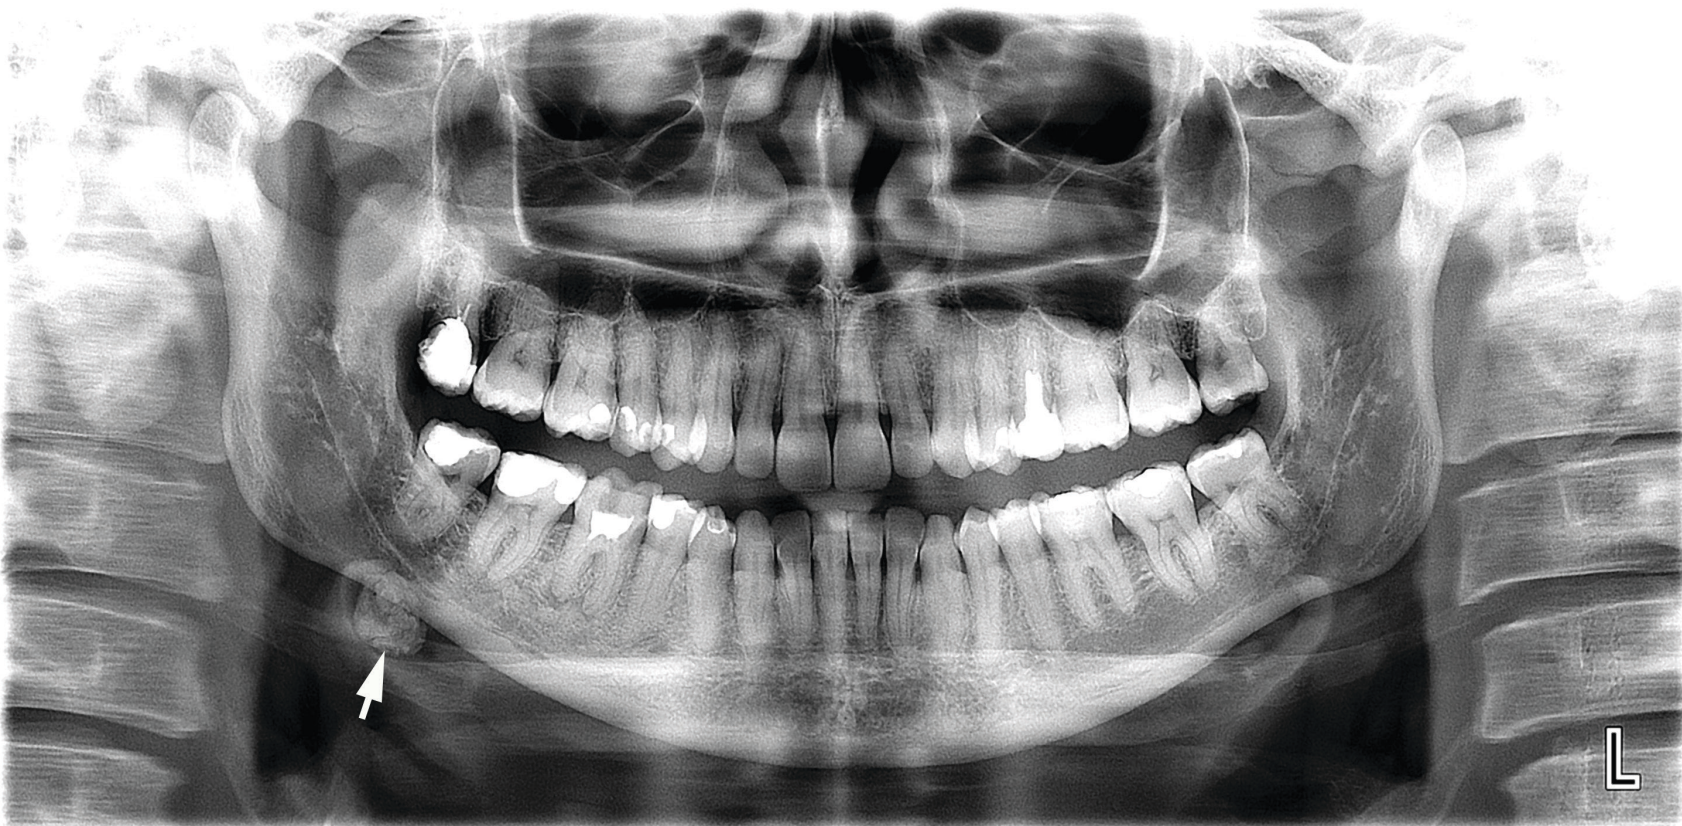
Case 6: An orthopantomogram of 46-year-old lady with a radiopaque sialolith (*arrow*) at the level of right submandibular gland.
